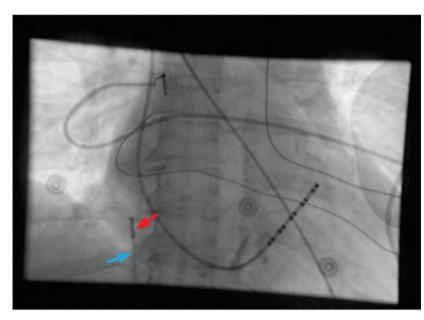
Fluoroscopic orientation of the intracardiac echocardiography (ICE) catheter (shown in anteroposterior projection) to obtain the "home view". A slight tilt/ rotation (as shown in the figure) may sometimes be required to obtain an adequate home view. Blue arrow = catheter shaft; red arrow = ultrasound transducer
